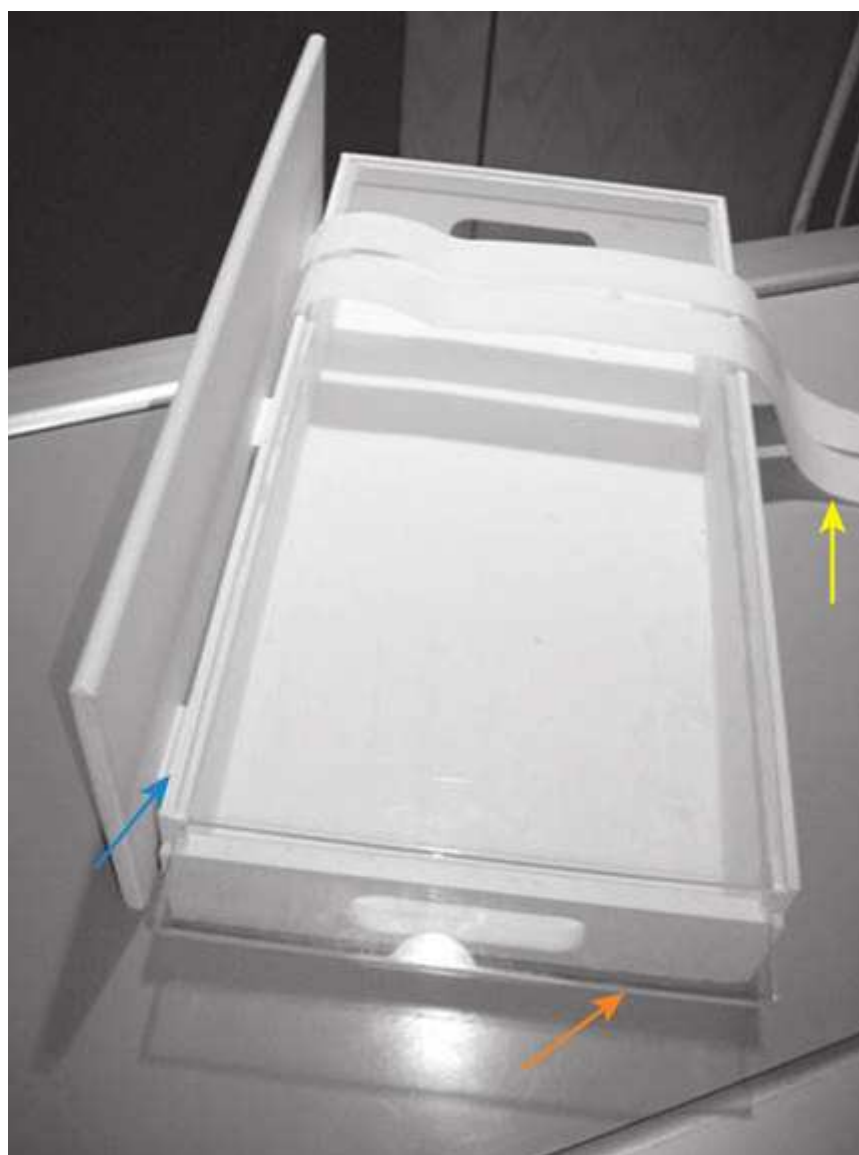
The baby box aids in the immobilization of an infant (0 to 12 months) for AP and cross-table lateral chest x-rays, soft tissue neck and C-spine imaging. There is a sliding tray (*orange arrow*) that holds the imaging plate for supine positions, a slot on the side (*blue arrow*) holds the IR for cross-table work, and Velcro straps (*yellow arrow*) are used to immobilize.
